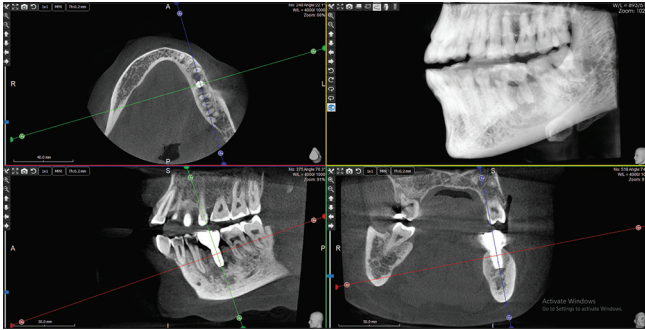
CBCT radiograph obtained the year following completion of treatment, indicating progressive bone gain around the implant and the distal root surface of tooth #20
